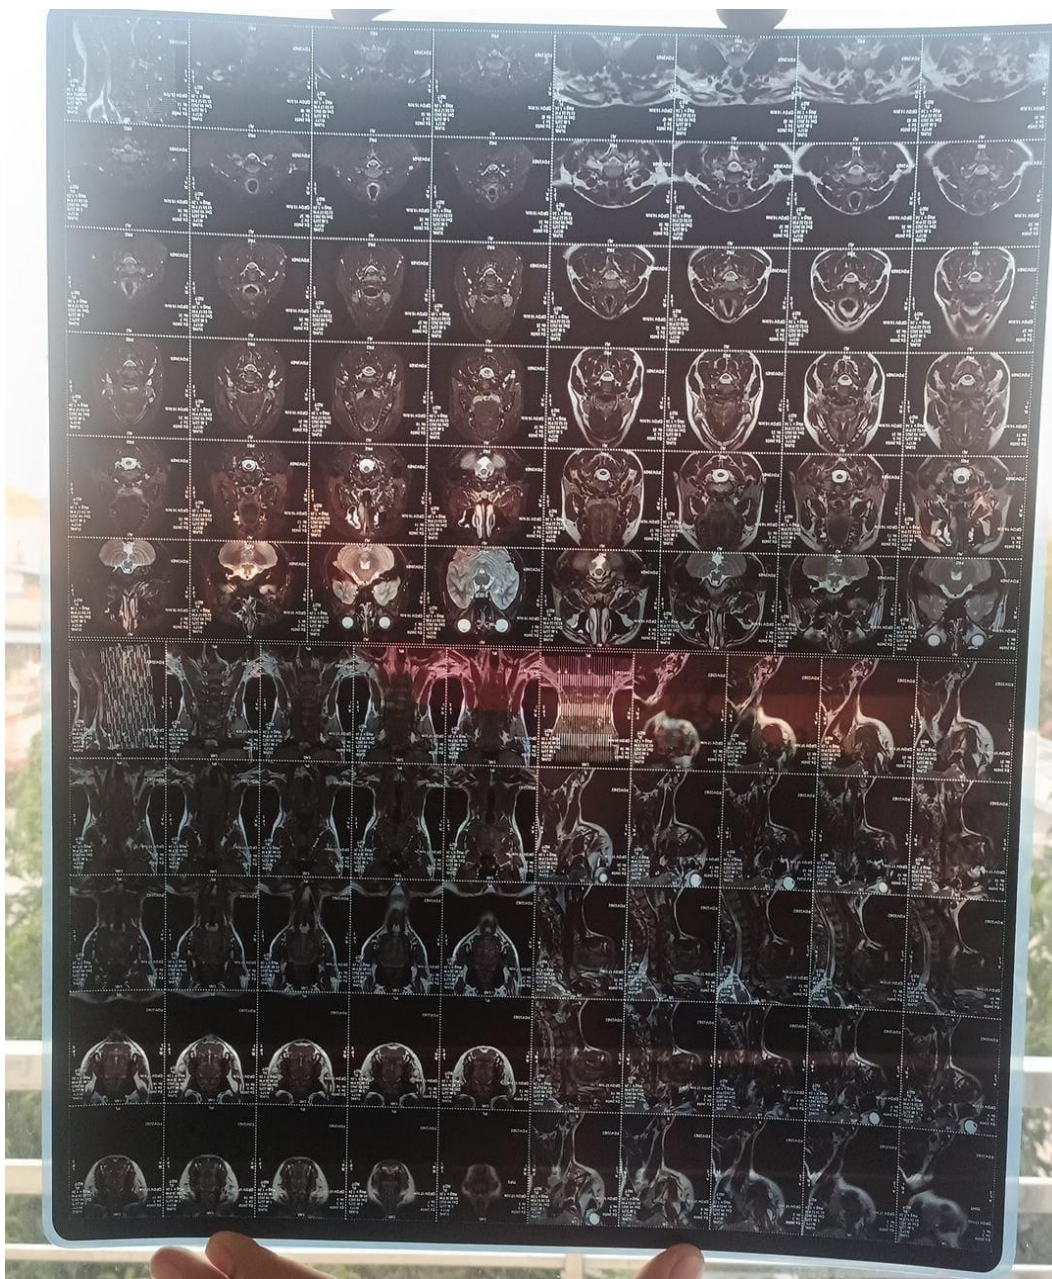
MRI Scan of the Head and Neck Region: Cross-Sectional Views for Diagnostic Evaluation of Cervical Pathology.
